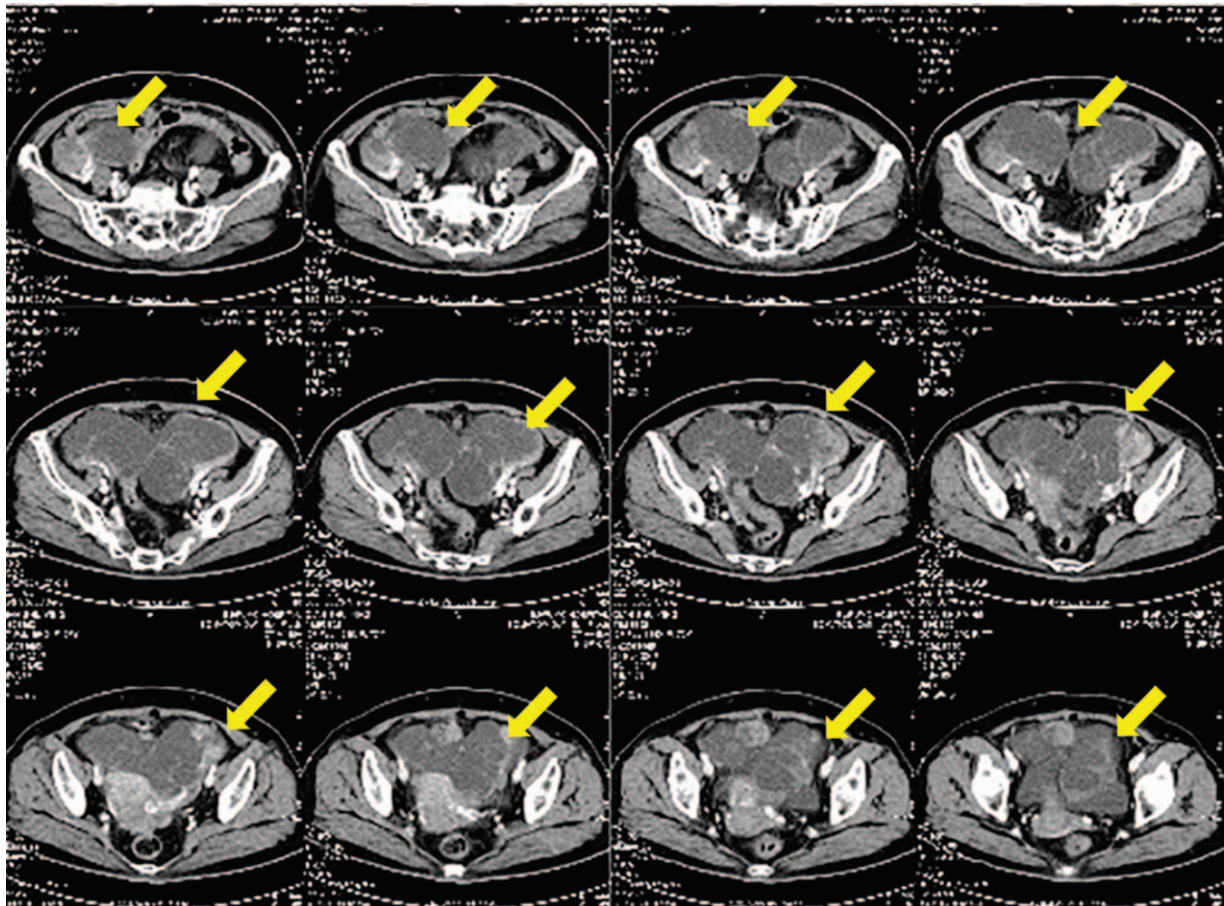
Case 3: Preoperative computed tomography images.
